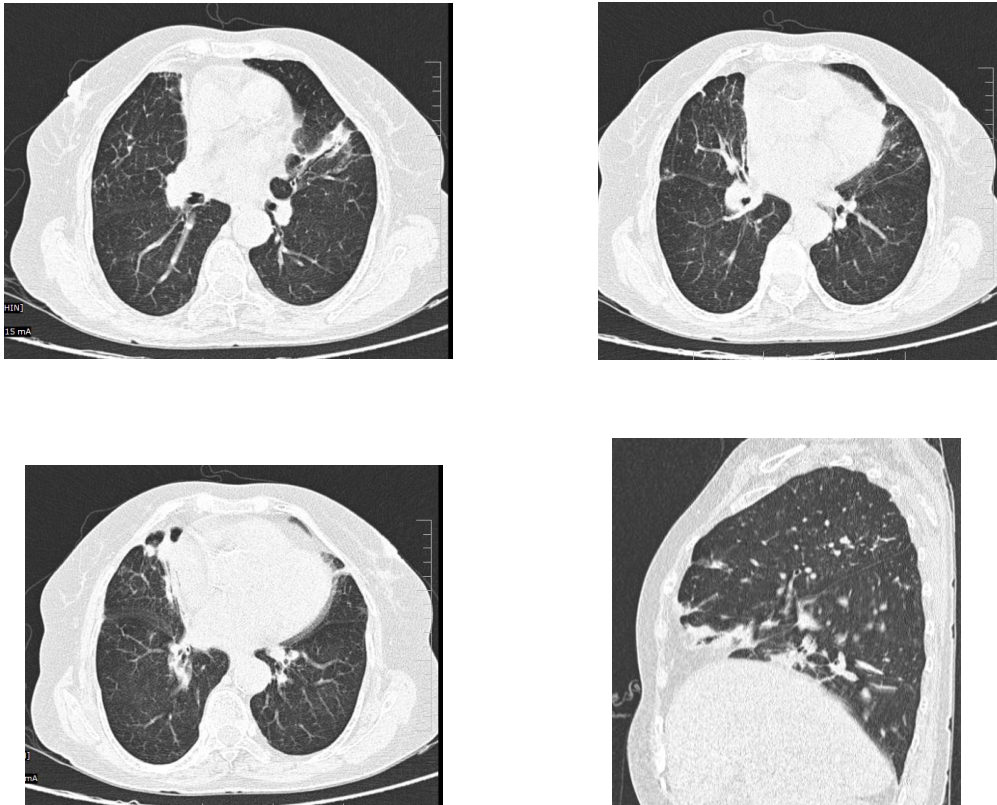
Axial and sagittal reformatted CT scan of chest in lung window demonstrating atelectatic changes with bronchiectasis involving right middle and lingular lobes.
